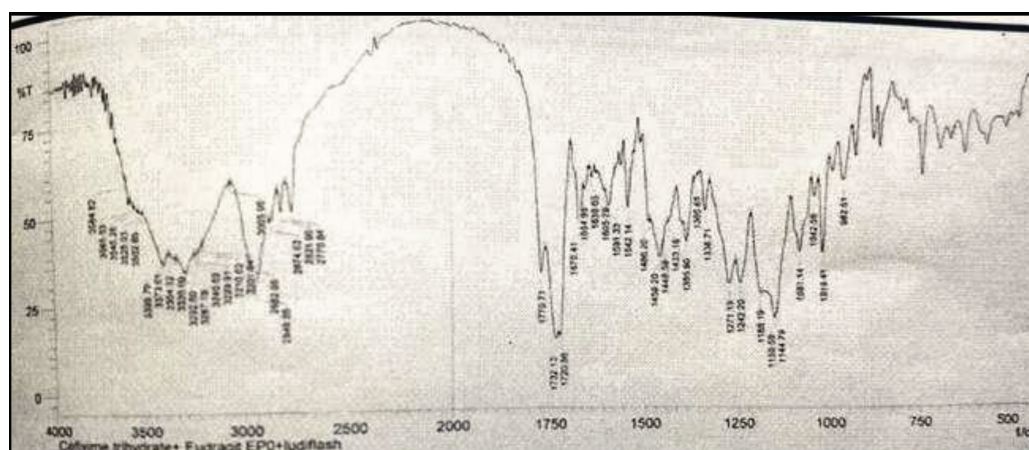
FTIR of FF5 ODMTs (CT + optimised EPO microcapsules + ludiflash)
